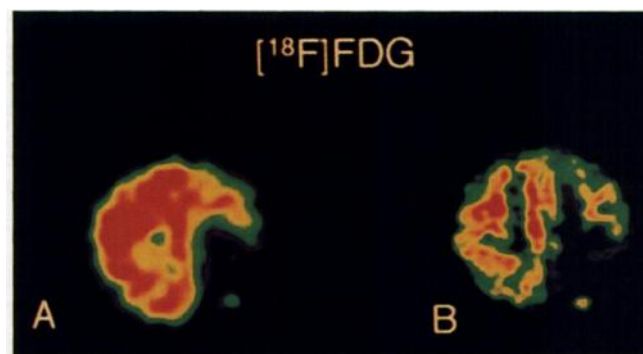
Images of 69-y-old man with left parietal glioblastoma surgically treated 1 y before PET study. Small lesion (~6 mm) was found on MRI. High FDG uptake, consistent with tumor recurrence, is seen on both DH-PET (A) and Ring-PET (B) transaxial images.
